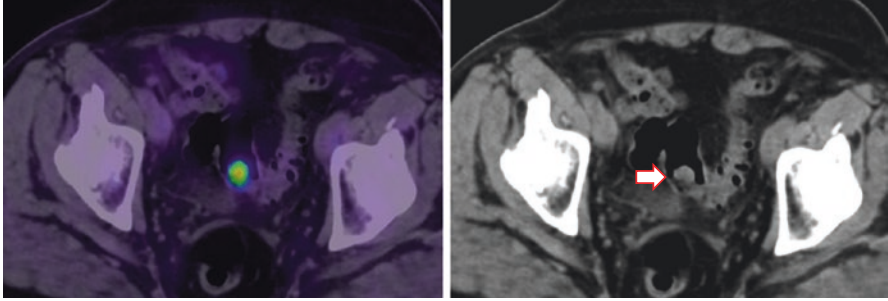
Incidentally detected intense FDG uptake in a sigmoid polyp (*red arrow*), which on colonoscopy and biopsy was found to be malignant
